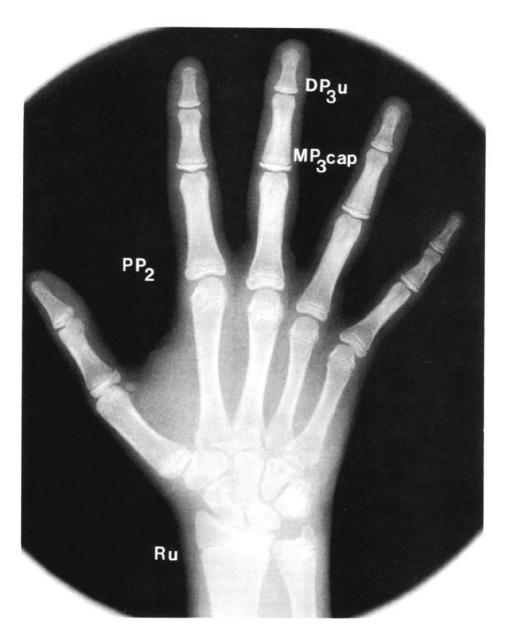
Radiograph of a hand, showing the ossification centers used for classification of skeletal development.
